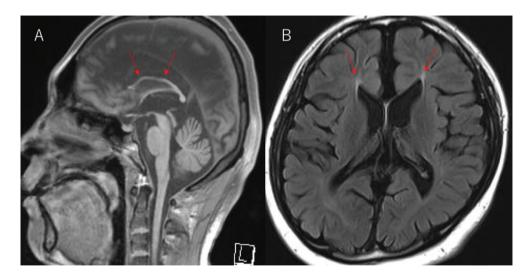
Brain MRI findings of the SPG11 patient. (A) Sagittal T1 image showing a thin corpus callosum, especially the anterior part. (B) Axial FLAIR image showed subtle ears of the lynx formation at the anterior periventricular portions of the lateral ventricles.
